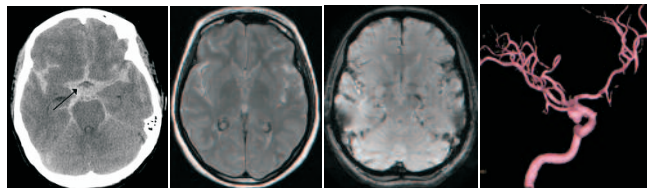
(a) Axial CT (b) FLAIR Axial (c) SWAN Axial (d) Volume rendering angiography
